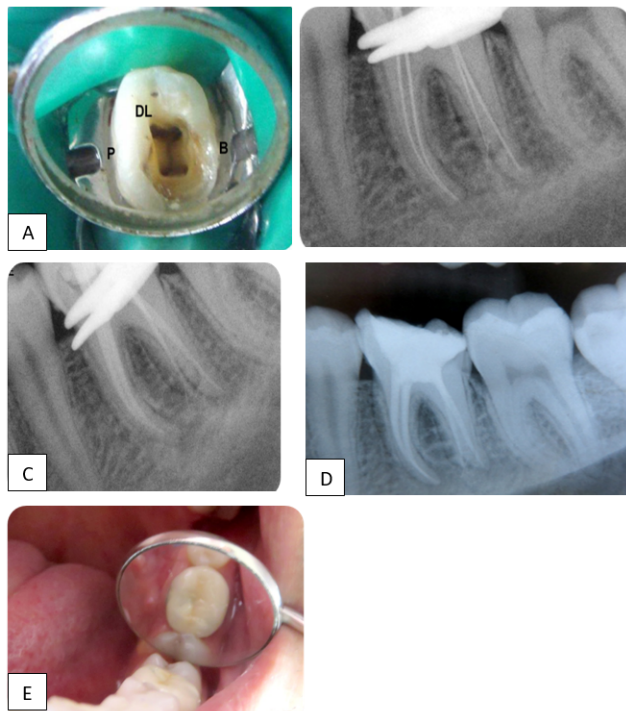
A): Access cavity; B): Working length radiograph; C): Mastercone radiograph; D): Post-operative radiograph; E): Crown luted
